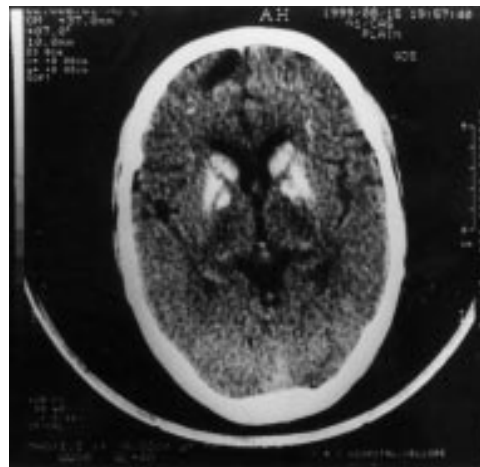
Computed tomography of the brain.
